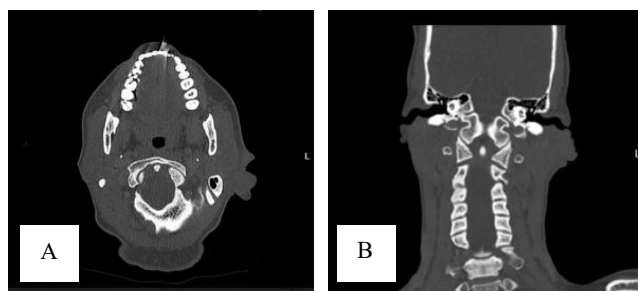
(A and B): CT scan of the head and neck shows a well-defined soft tissue mass in the left auricular region no evidence of local infiltration.
